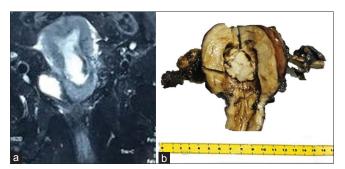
(a) Contrast-enhanced computed tomography scan showing the tumor in the endometrial cavity. (b) The gross image of the tumor in the endometrial cavity arising from the fundus
